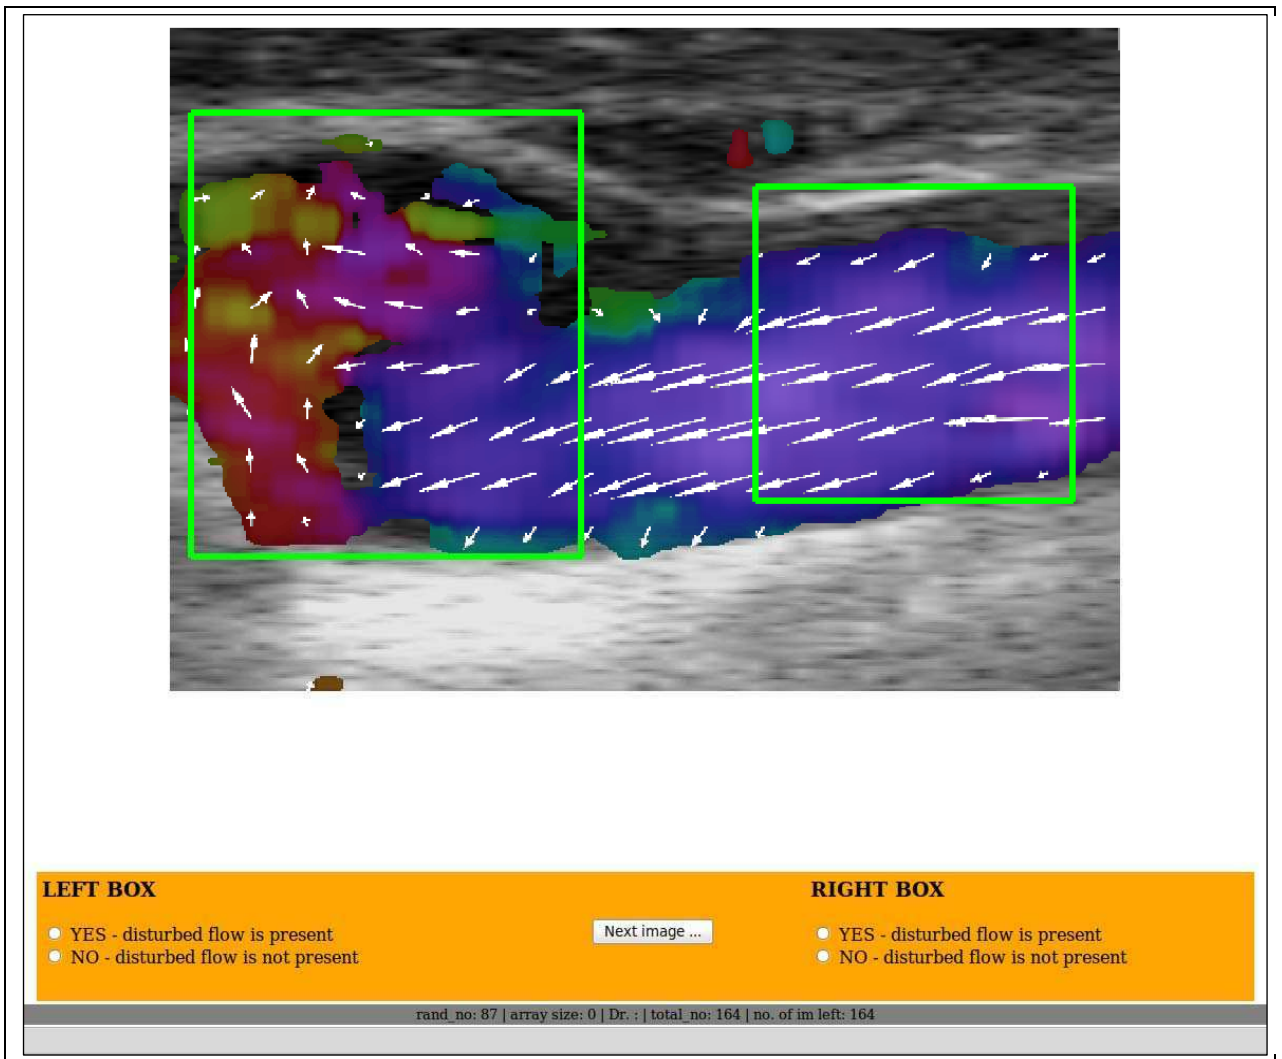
Demonstration of an image frame used for visual assessment by ultrasound experts. The cropped image included two outlined areas. The green boxes define the common carotid area (right) and carotid bulb (left). Each of the 164 frames available from the eight volunteers was presented randomly to the experts using a web interface.
